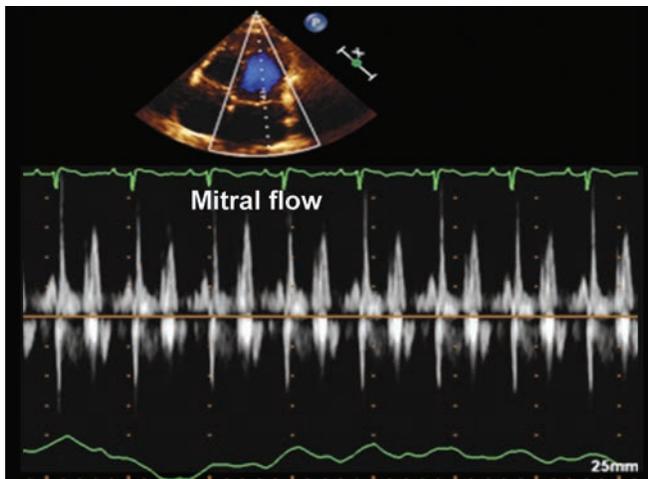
Mitral flow Doppler.
